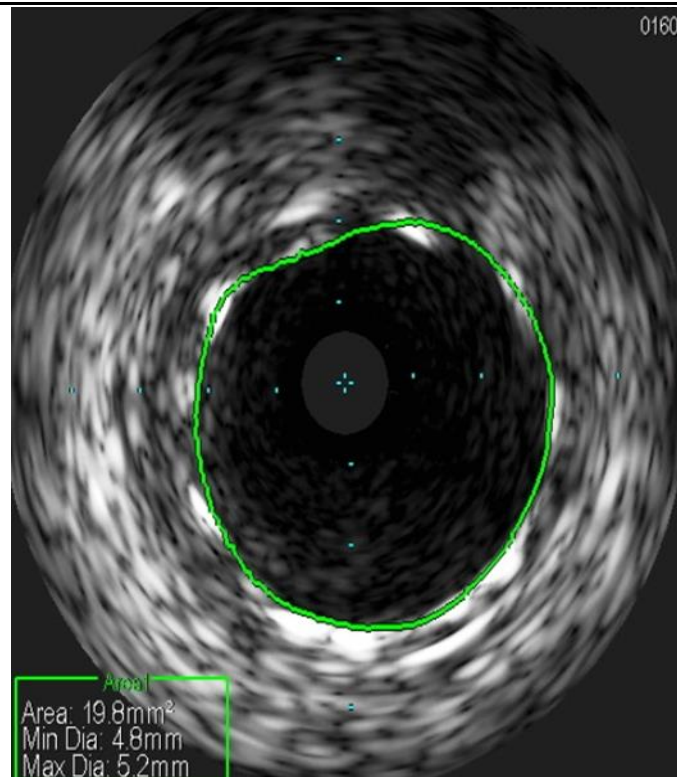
Post stenting intravascular ultrasound (minimal luminal area of 19.8mm²)
